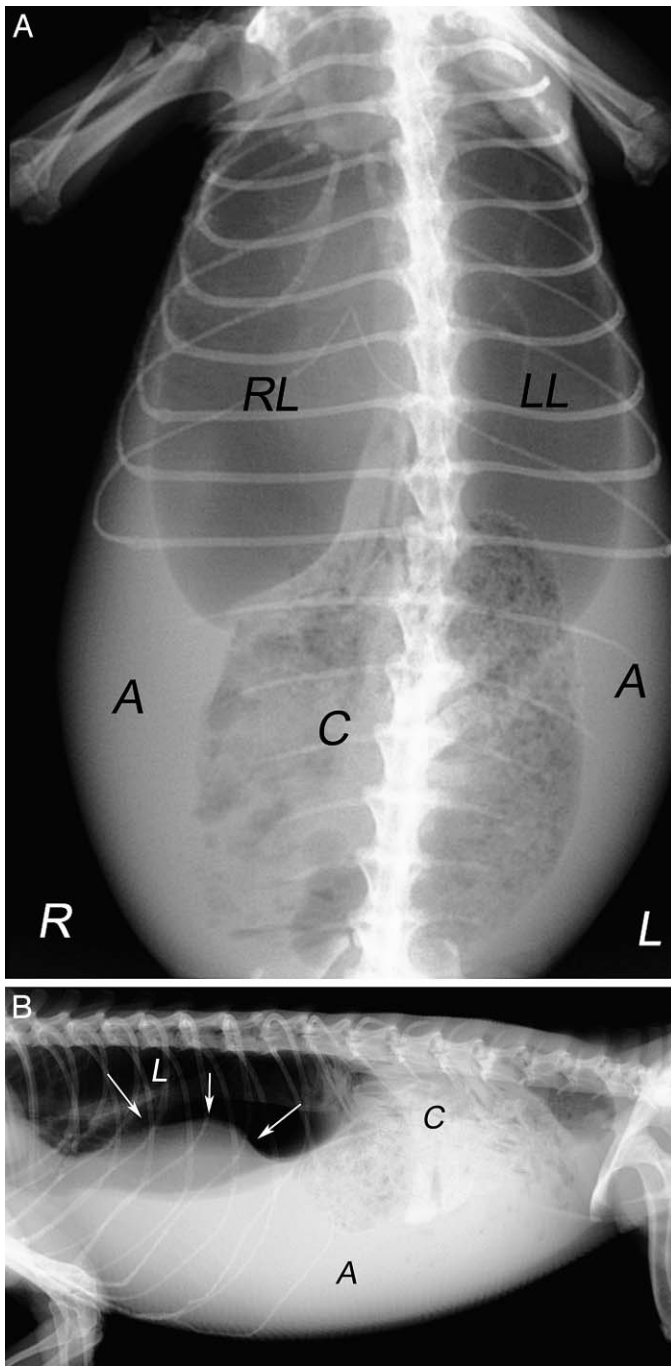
(A) Ventrodorsal radiographic image. Coelomic fluid opacity (ascites) around lungs restricts visualization of viscera: A = ascites, RL = right lung, LL = left lung, C = cecum (enlarged). (B) Lateral radiographic image showing soft tissue opacity (white arrows) and fluid density (A) in the coelomic cavity. A = ascites, L = lungs, C = cecum (enlarged).
